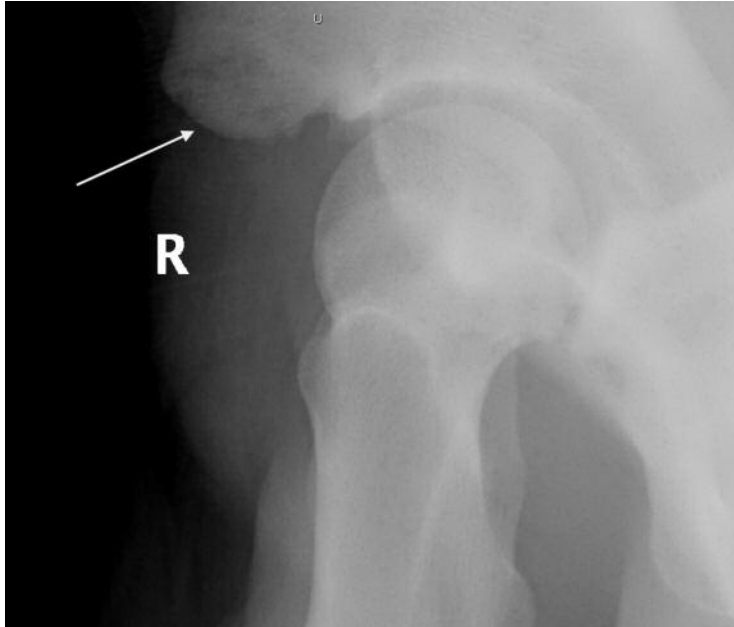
False profile X-ray view demonstrating AIIS bony prominence (white arrow).
